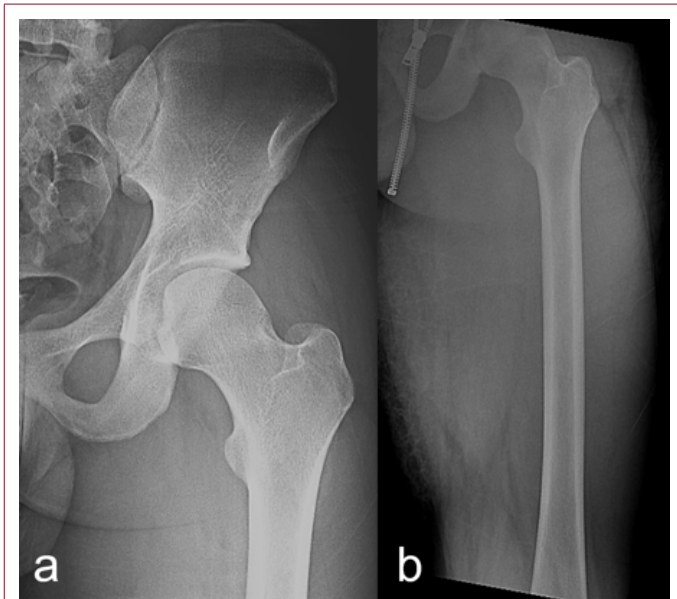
Anteroposterior radiographs of the pelvis (a) and left femur (b) were obtained at the initial presentation to the emergency department. No acute bony abnormalities or fractures were identified.
